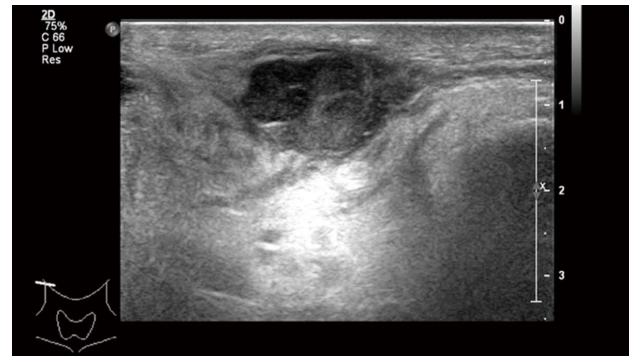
Ultrasonogram of the neck showed a 15 mm × 27 mm mass in the right parotid gland.
